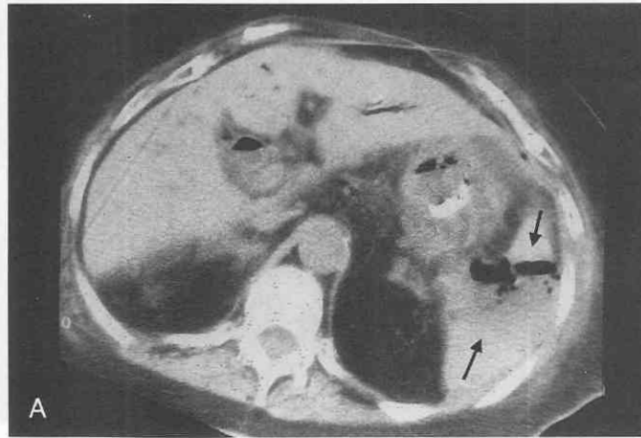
CT scans showing splenic abscesses. *A*, Unenhanced scan demonstrates a low-attenuation splenic abscess (arrows) with gas. *B*, Splenic abscess mass effect and complex fluid. *C*, Unenhanced scan shows two abscesses in the lower pole of the spleen (arrows).
